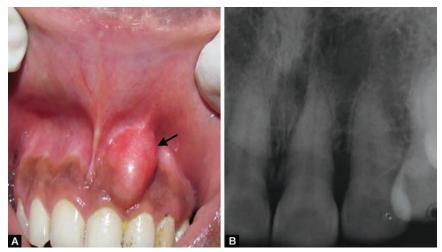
(A): Clinical picture of the girl shows the intraoral swelling present on left side of anterior maxilla (arrow). (B): intraoral periapical radiograph of maxillary left central and lateral incisors shows normal bone
